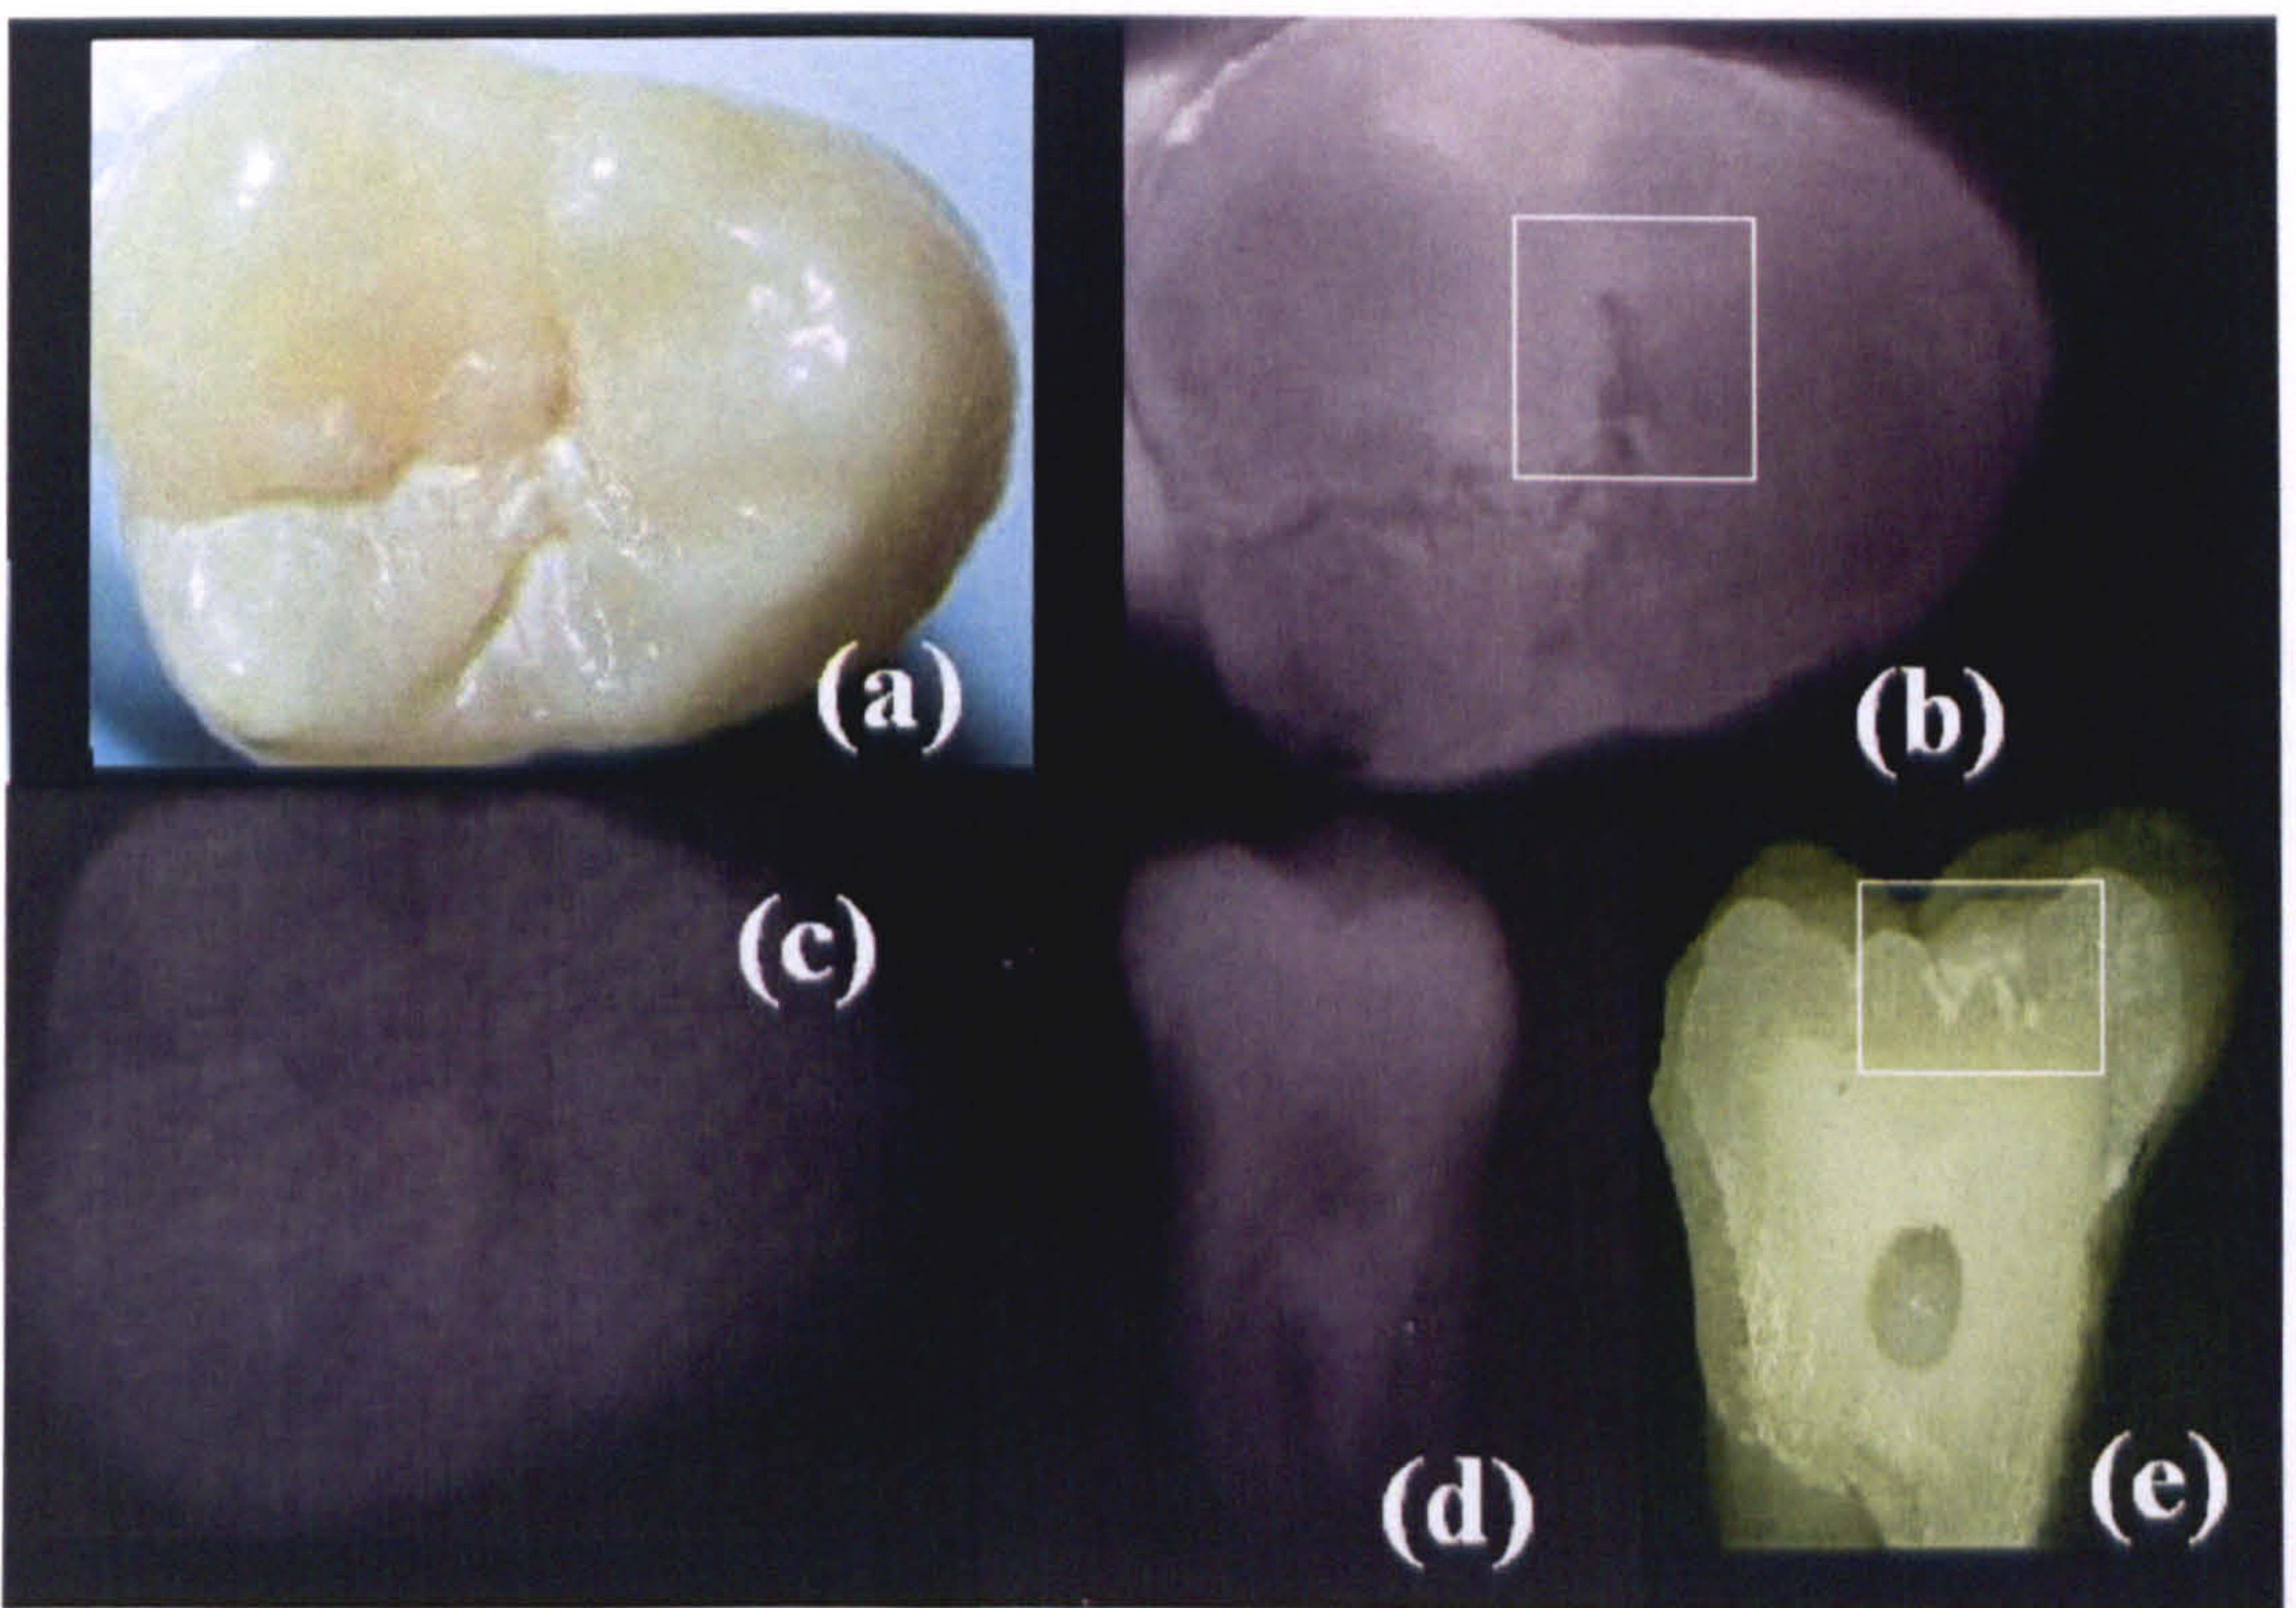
Showing images of a supposedly sound tooth (*sound 2*) using the various techniques: (a) Visual Inspection, (b) Lateral Illumination, (c) QLF, (d) Bitewing X-ray photography, (e) Visual Inspection after dissection.
